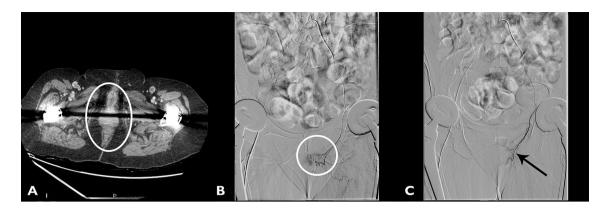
74-year-old patient hospitalized for chronic metrorrhagia. a CT scan shows vulvar cancer spread to perineum. b Diagnostic superselective DSA through a 2.7 Fr microcatheter (white circle)
